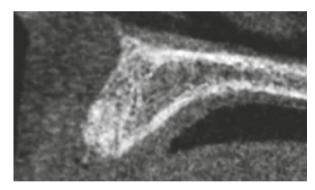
CBCT at 4 months of healing with integrated bone graft.
